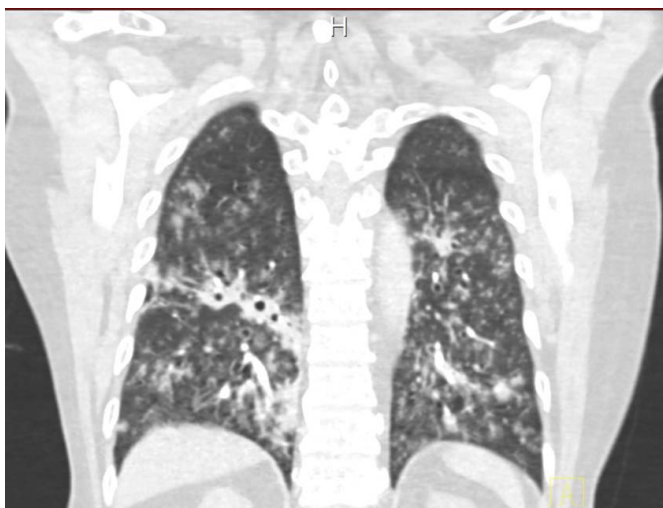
Non enhanced coronal view high resolution CT chest.
